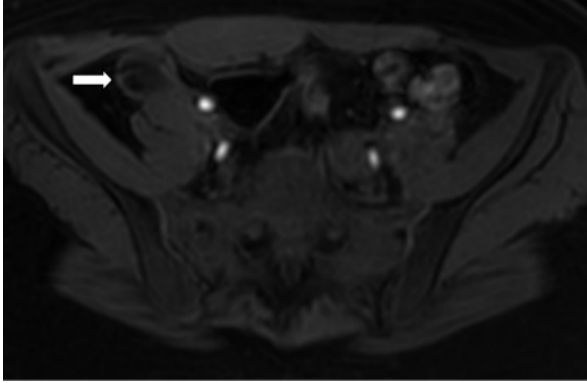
T1 SAT MRI images of pelvis showing loss T1 hyperintense rim of the ovarian mass suggesting fat stranding
